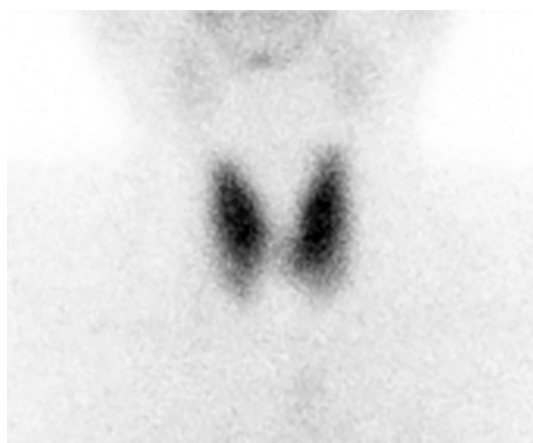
Thyroid ^{99m}Tc scintigraphy showed the normal uptake of technetium into the thyroid (2.2%, normal: 0.5-3.5).
